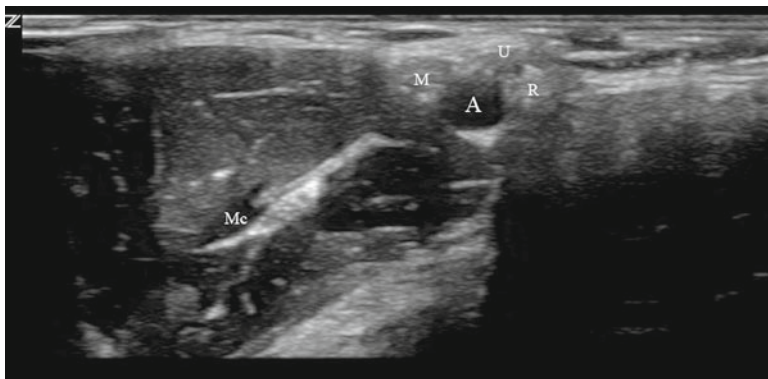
Ultrasonographic appearance of the axillary brachial plexus (A axillary artery, M median nerve, Mc musculocutaneous nerve, R radial nerve, U ulnar nerve)
